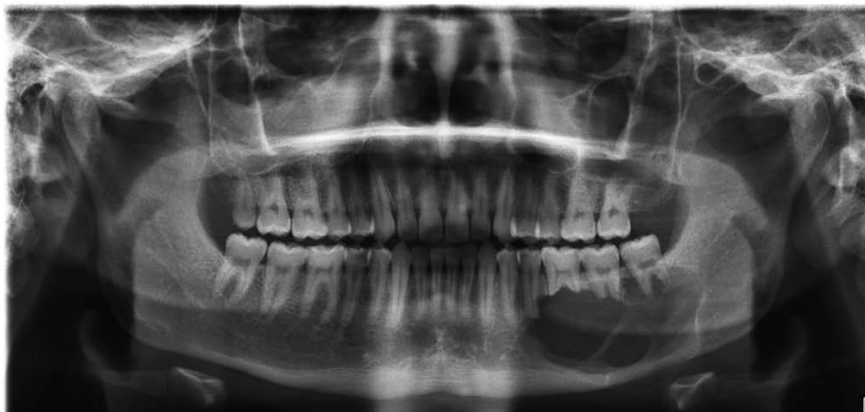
Panoramic radiograph showing multi-locular lesion in the mandibular posterior region.
